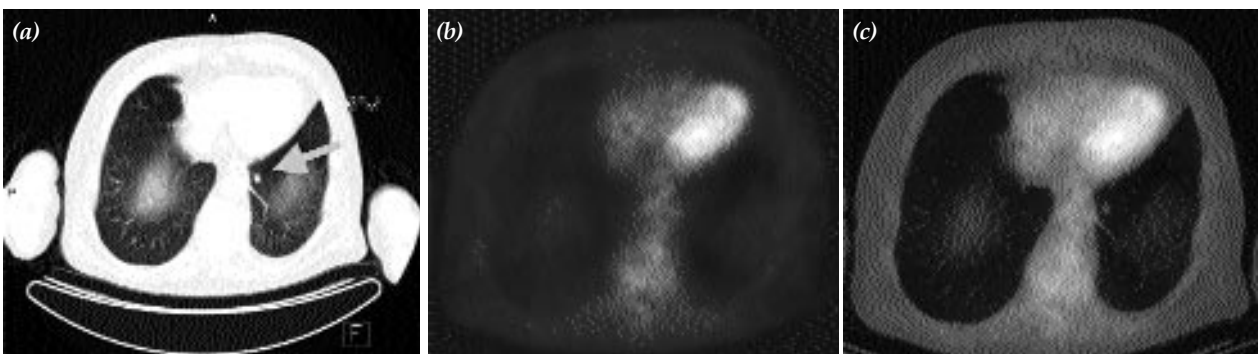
Head and neck cancer with small lung metastasis is only visualized on CT. (a) Circular focus (green arrow) of suspicious malignant growth in the medial left low lobe of the lung in CT (b) without activity accumulation in PET and (c) superposition. Further history revealed a metastasis of laryngeal cancer.
